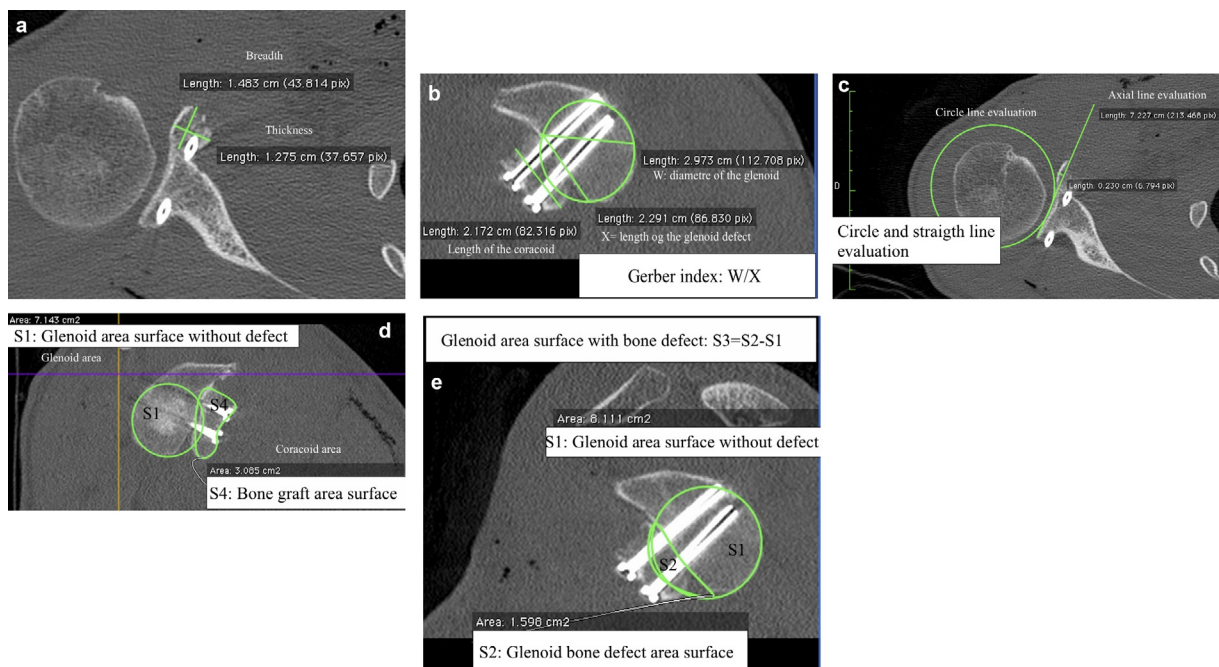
CT assessment: a: graft thickness and width; b: Gerber index (W/X) and graft length; c: line and circle assessment of graft positioning on glenoid; d: glenoid area 1 (without defect), and area 4 (graft area); e: area 1 and defect area (area 2); area 3: glenoid area before graft: $A3 = A1 - A2$.
